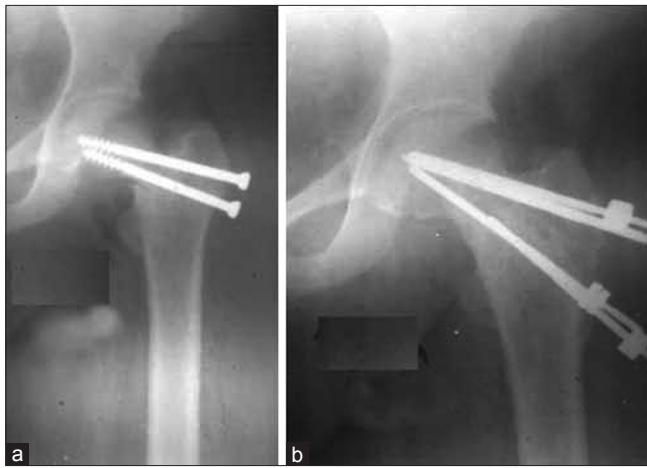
X-ray left hip joint anteroposterior view in a 30 year old lady showing (a) nonunion since six months, previously treated with cancellous screws; neck shaft angle is 105°, (b) a followup X-ray film at two years with good union and neck shaft angle restored to 136°
